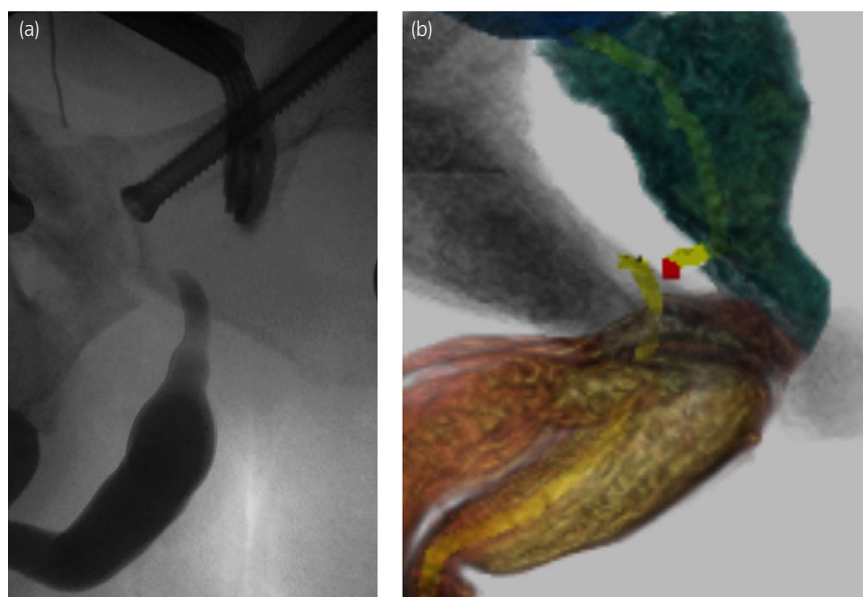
(a) Combined ante- and retrograde urethrogram of Case 2. Note posterior distraction of the proximal stump. (b) VR image of the urethra, created from thin-slice MRI image from the same patient as (a). Urethra is marked in yellow, and the scar, in red. Posterior deviation of the proximal stump is shown by sagittal view, corresponding to urethrogram similar to (a).
